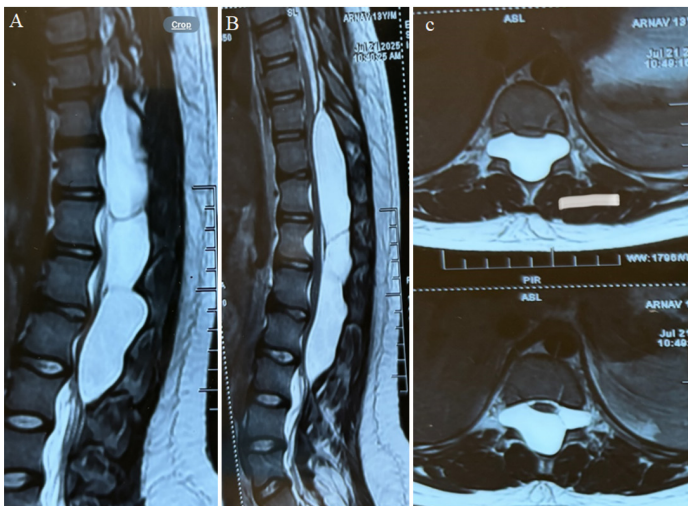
(A) Sagittal T2-weighted image of the thoracic spine reveals loculated arachnoid cysts separated by fibrous septa. The spinal cord is compressed and displaced to the anterior of the spinal canal. (B) On sagittal T2-weighted image of the lumbar spine, another location of the arachnoid cyst is seen, located at L1-L3 levels and separated from the superior one with fibrous septa. (C) Axial T2-weighted image from distal thoracic level shows extra dural loculated arachnoid cyst compressing the spinal cord.
